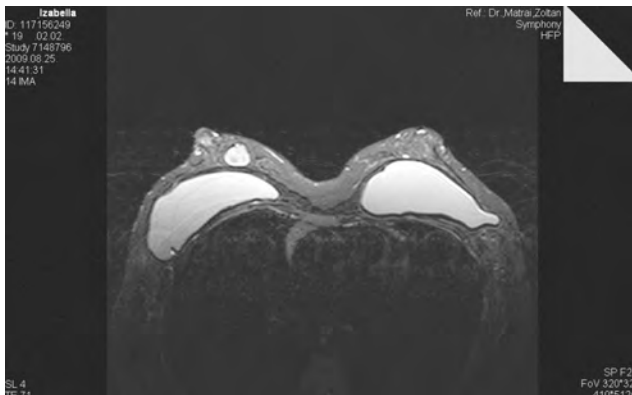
a/b: Preoperative MR images of the breasts: the morphologic features of most of the fibroadenomas were generally similar, consisting of smooth margins and round or lobulated shape. Inner septations with heterogeneous structures have been found in a marked part of the tumors, making the accurate differentiation of phyllodes tumors or even of malignant neoplasms impossible.
